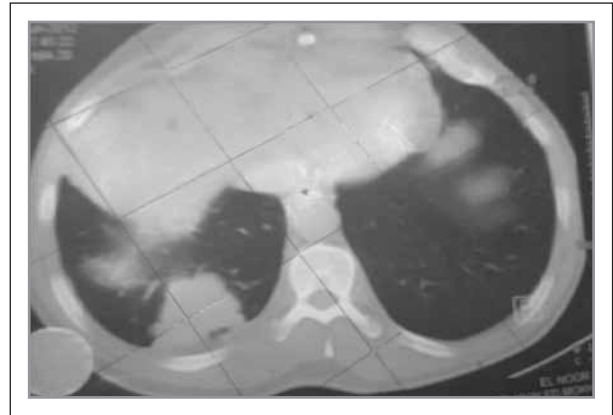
Photo was showing CT chest with peripheral NSCLC stage 1 in right lower lobe
